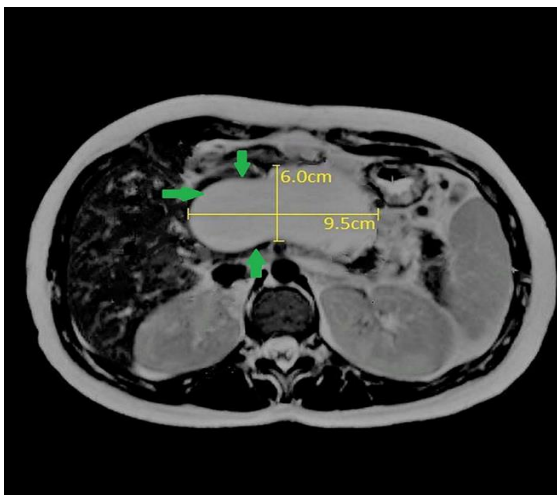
Axial T2-weighted MRI of a pancreatic pseudocyst. The green arrows point to a 9.5 x 6 cm fluid-containing, encapsulated lesion adjacent to the body of the pancreas.
